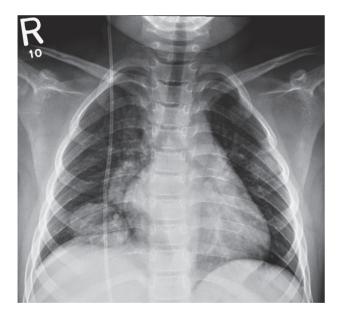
Follow-up frontal chest x-ray shows interval development of bilateral lung lesions, the largest one in the right lower lobe. The cardiomediastinal silhouette is normal.
